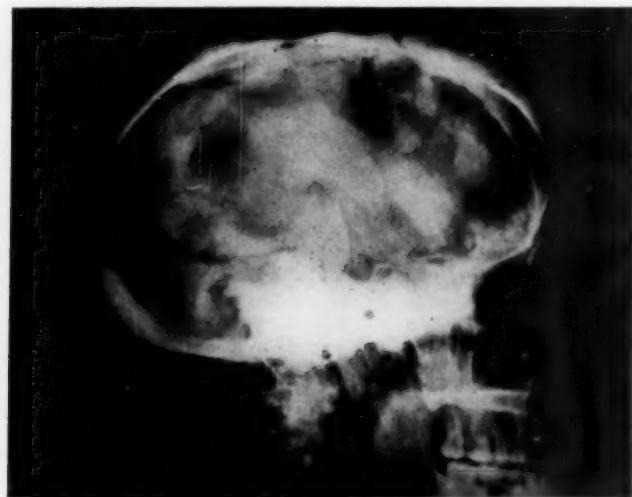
Case 19. Skull roentgen-ray. Geographic skull.
